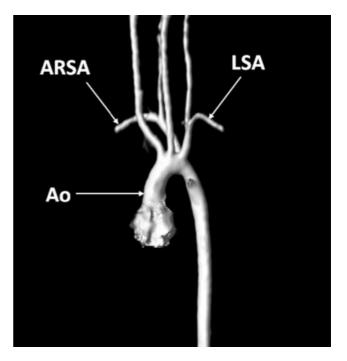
Postnatal magnetic resonance image demonstrating an aberrant right subclavian artery (ARSA) arising from the descending aorta (Ao). Note that the course of an ARSA would not be seen in a standard long-axis view of the aortic arch. LSA, left subclavian artery.
